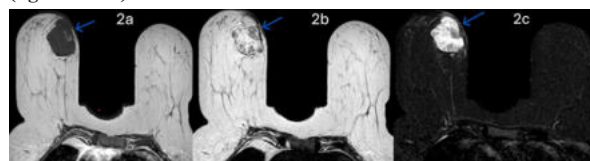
On MRI breast shows a T1w T2w & STIR shows a 5.2 x 4 x 3.5 cms heterogenous lesion (blue arrow) with spiculated border and disrupted perilesional halo in the inner aspect of right breast extending to the retro areolar region. One component extends to subcutaneous plane, the lesion appeared hypointense on T1W (2a) with focal hyperintensity seen at periphery possibly haemorrhage and Heterogenous predominantly hyperintense with multiple areas of hypo intensity within it on T2W (2b) and STIR(2c) sequences.
